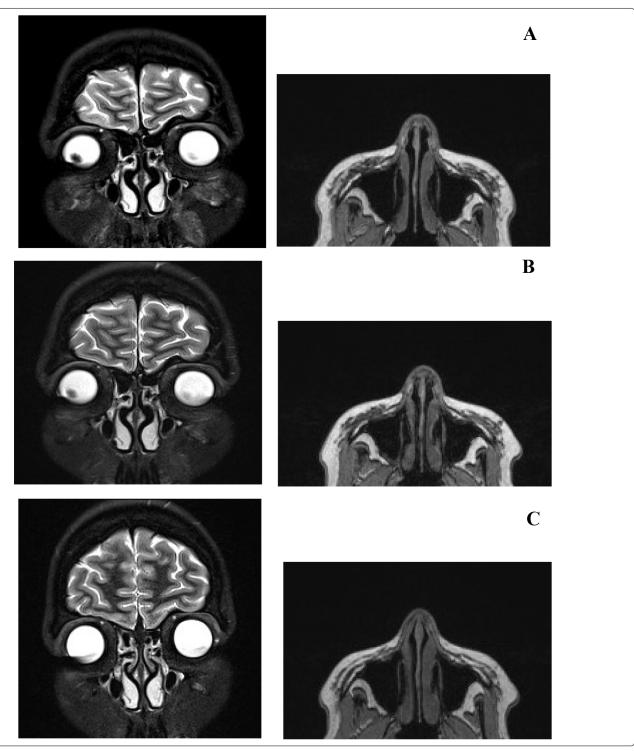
MRI of the maxillofacial region. (A) MRI in the coronal and axial projections 3 days after the injection of CaHA-based drugs. MRI images demonstrate symmetrical distribution of the injected drugs as a "depot" in the middle third of the face in the periosteal region at the level of the zygomatic bones on the right and left. (B) MRI in the coronal and axial projections 1 month after the injection of CaHA-based drugs. MRI images demonstrate symmetrical distribution of the injected drugs in the middle third of the face in the periosteal region at the level of the zygomatic bones on the right and left. (C) MRI in the coronal and axial projections 12 months after the injection of CaHA-based drugs. MRI images demonstrate almost complete biodegradation of the gel carrier of CaHA-based drugs in the middle third of the face in the periosteal region at the level of the zygomatic bones on the right and left.
